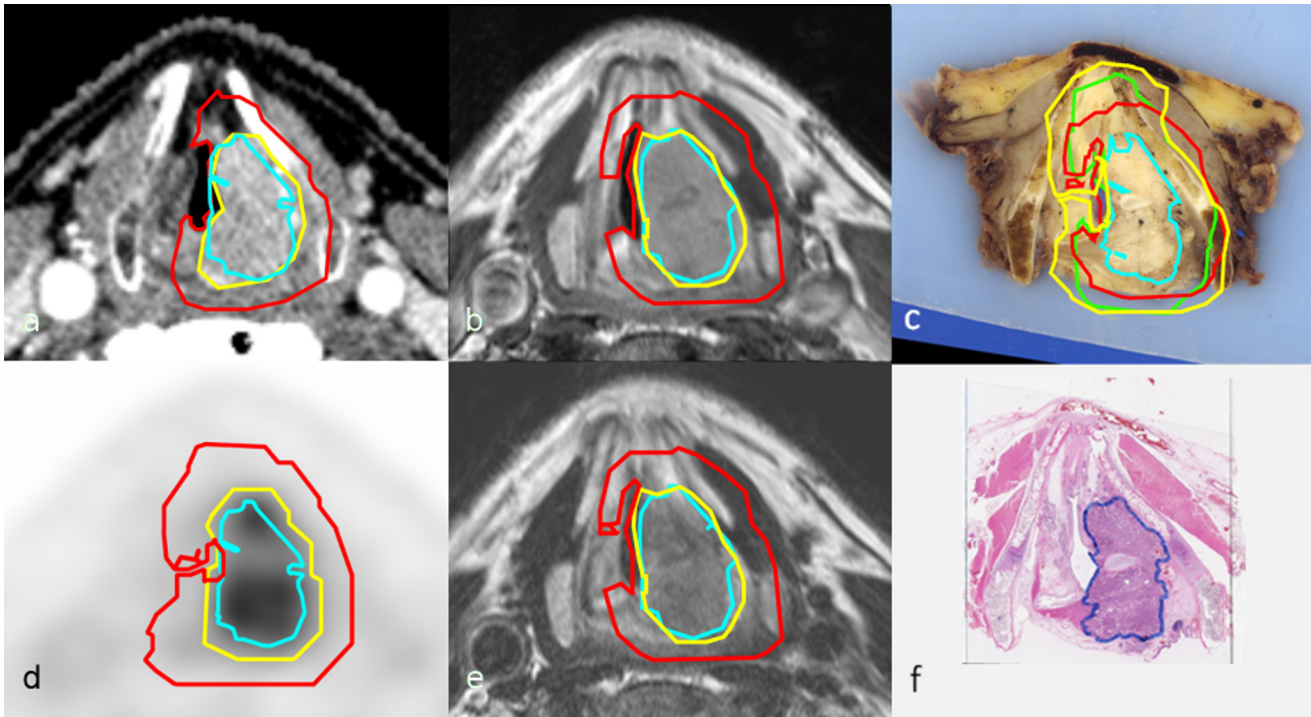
Laryngeal tumor delineated on (a) contrast-enhanced CT, (b, e) MRI (T₁-weighted Gd-enhanced, T₂ weighted, respectively) and (d) FDG-PET with corresponding (c) macro- and (f) histo-pathology of patient 34 with a T4 stage glottic laryngeal carcinoma. For a, b, d and e the contours of tumor_{HE} (blue), GTV (yellow) and CTV (red) are shown. For c, the contours of tumor_{HE} (blue) and CTV_{CT} (green), CTV_{MRI} (red) and CTV_{PET} (yellow) are given. In f, the manually delineated pathology contour (dark blue) is depicted. The tumor_{HE} contour shown in a–e is the non-rigidly transferred delineation of the pathology delineation shown in f. The difference of the pathology based tumor delineation between the imaging modalities is caused by slice thickness differences between MRI and CT/PET resulting in sampling differences.
